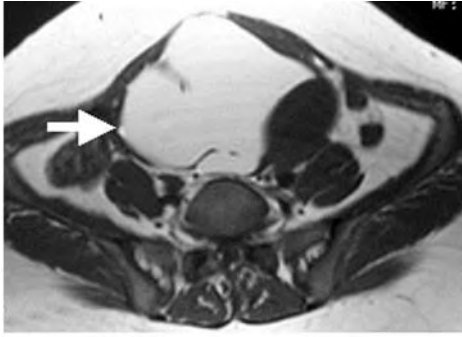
Benign cystic teratoma. (a) Axial T1-weighted, (b) axial and (c) sagittal T2-weighted, and (d) post-intravenous gadolinium-enhanced fat-suppressed T1-weighted images show a pelvic mass (arrows) lying above the uterus. The mass shows a fat-fluid level (arrowhead). The fat can be seen as high-signal intensity on both the T1- and T2-weighted scans and shows loss of signal on the fat-suppressed image, i.e. similar signal intensity to intrapelvic and subcutaneous fat.
